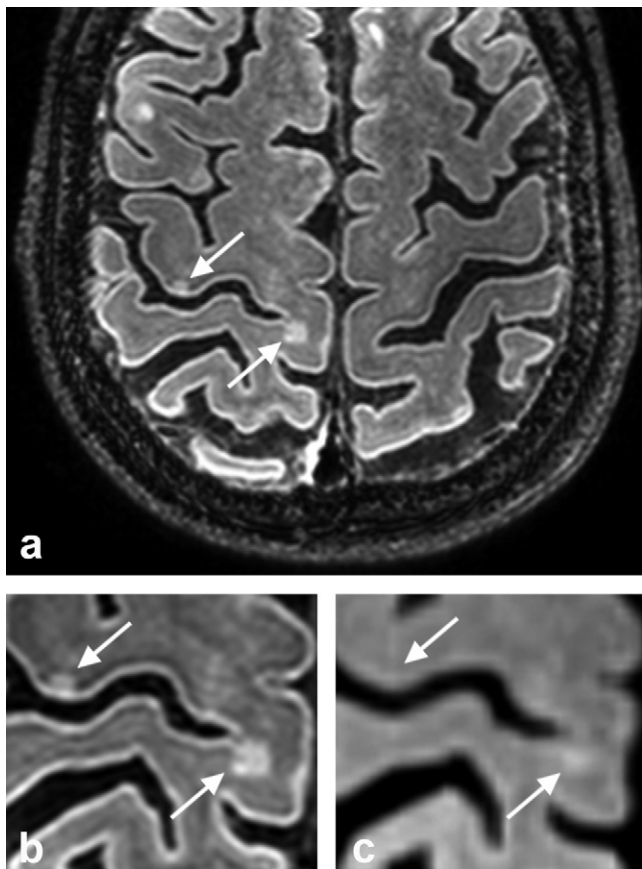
63-year-old female with primary progressive multiple sclerosis (MS) with an Expanded Disability Status Score (EDSS) of approximately 6.0. A 7 T MRI scan was performed for the detection of possible cortical lesions. a, Axial overview and b, zoomed-in image of a high parietal cortical MS lesion (right arrow) on axial 7 T 3D-FLAIR sequence. In retrospect, this lesion could also be seen on the 3 T 3D-FLAIR images, although with lower contrast-to-noise (c). The other cortical lesion (left arrow) on the other hand could not be seen at 3 T MRI. Imaging parameters 7 T 3D-FLAIR as previously published [3], 0.8 mm isotropic resolution; 3 T FLAIR 1.1 mm isotropic.
